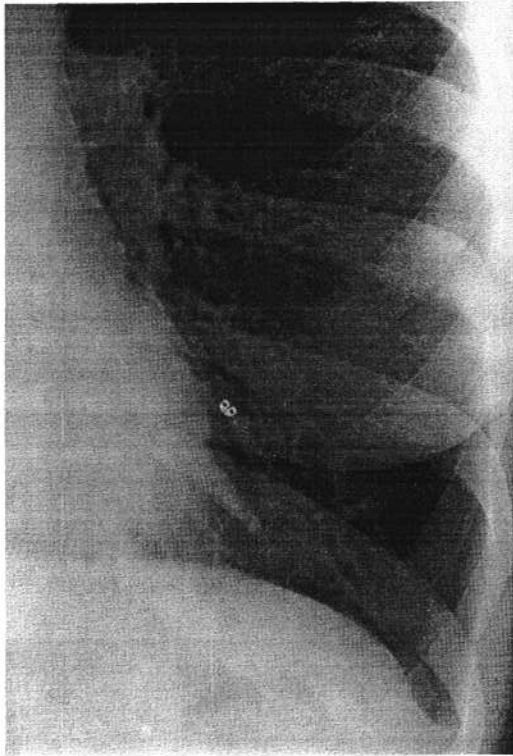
A magnified view of the patient's chest radiograph.
